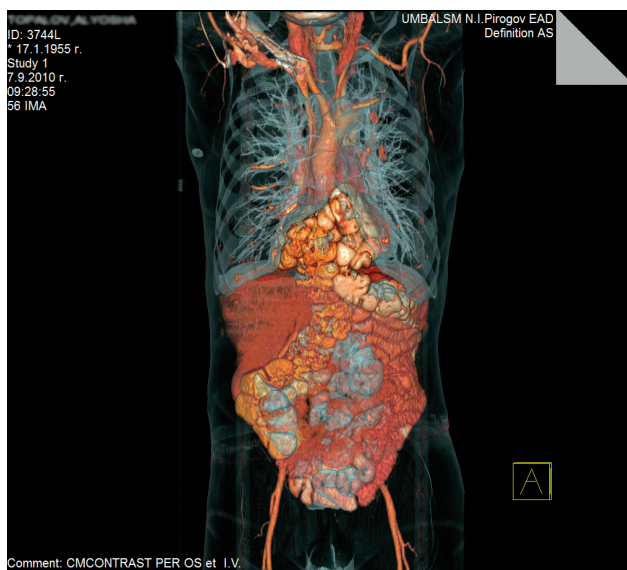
Preoperative three-dimensional computed tomography (3D-CT) showing a large Morgagni-Larrey hernia.
